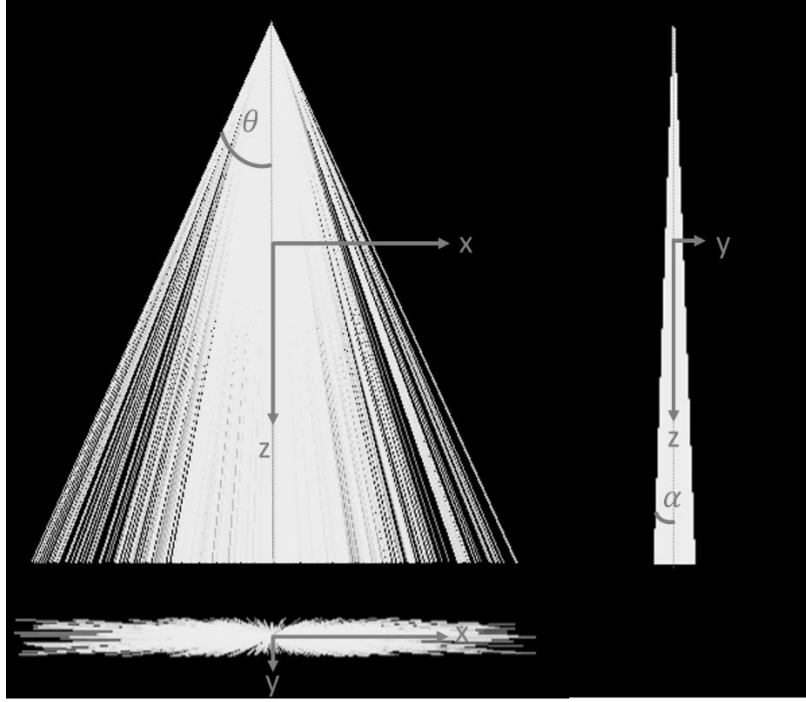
Example of photon track output of the implemented aluminium equivalent CT source and spatial orientation, from [1], Licensed under CC BY 4.0 (<https://creativecommons.org/licenses/by/4.0/>).
